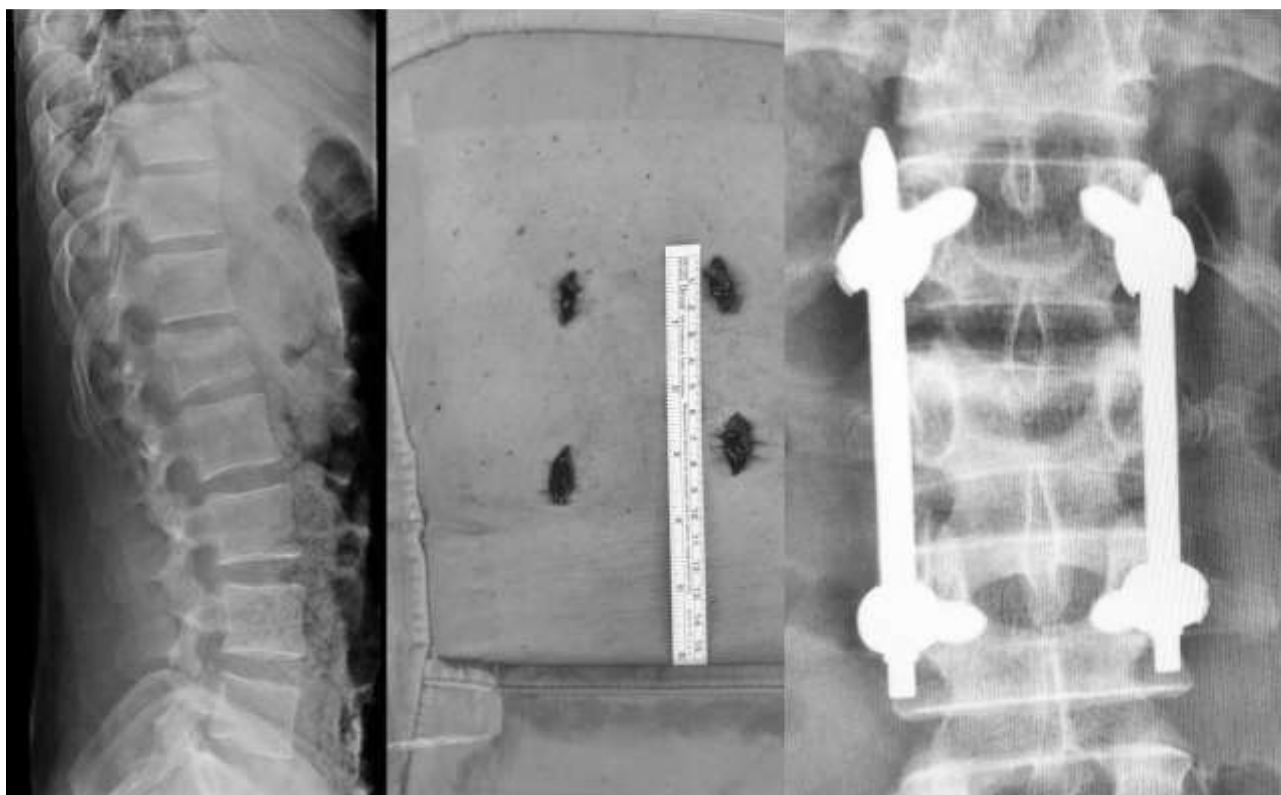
Preoperative X-Ray, the small access for the vertebral stabilization, postoperative X-Ray.
